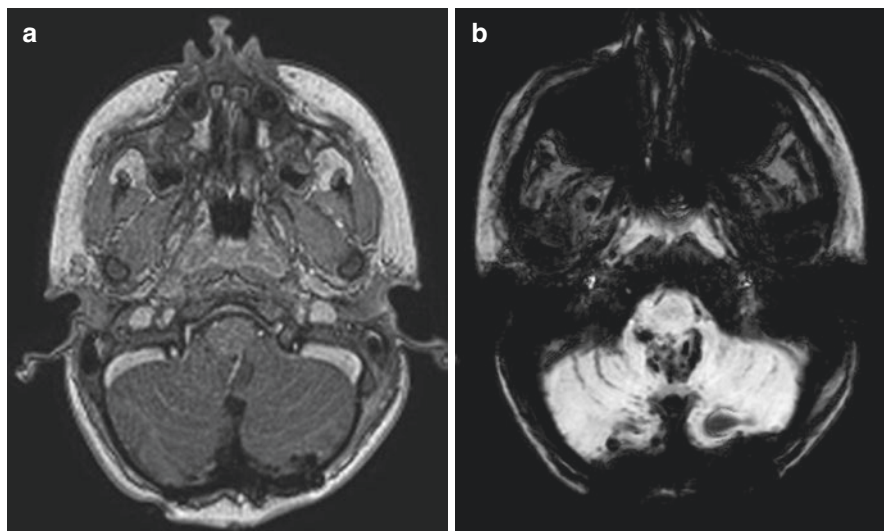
Normal post-operative appearance. Axial post-contrast SPGR MRI (a) at the level of the posterior fossa shows occipital craniectomy, and magnetic susceptibility sequence (b) demonstrated an amount of blood products along craniotomy and in the subarachnoid space, in (a) a profoundly hyposignal component
